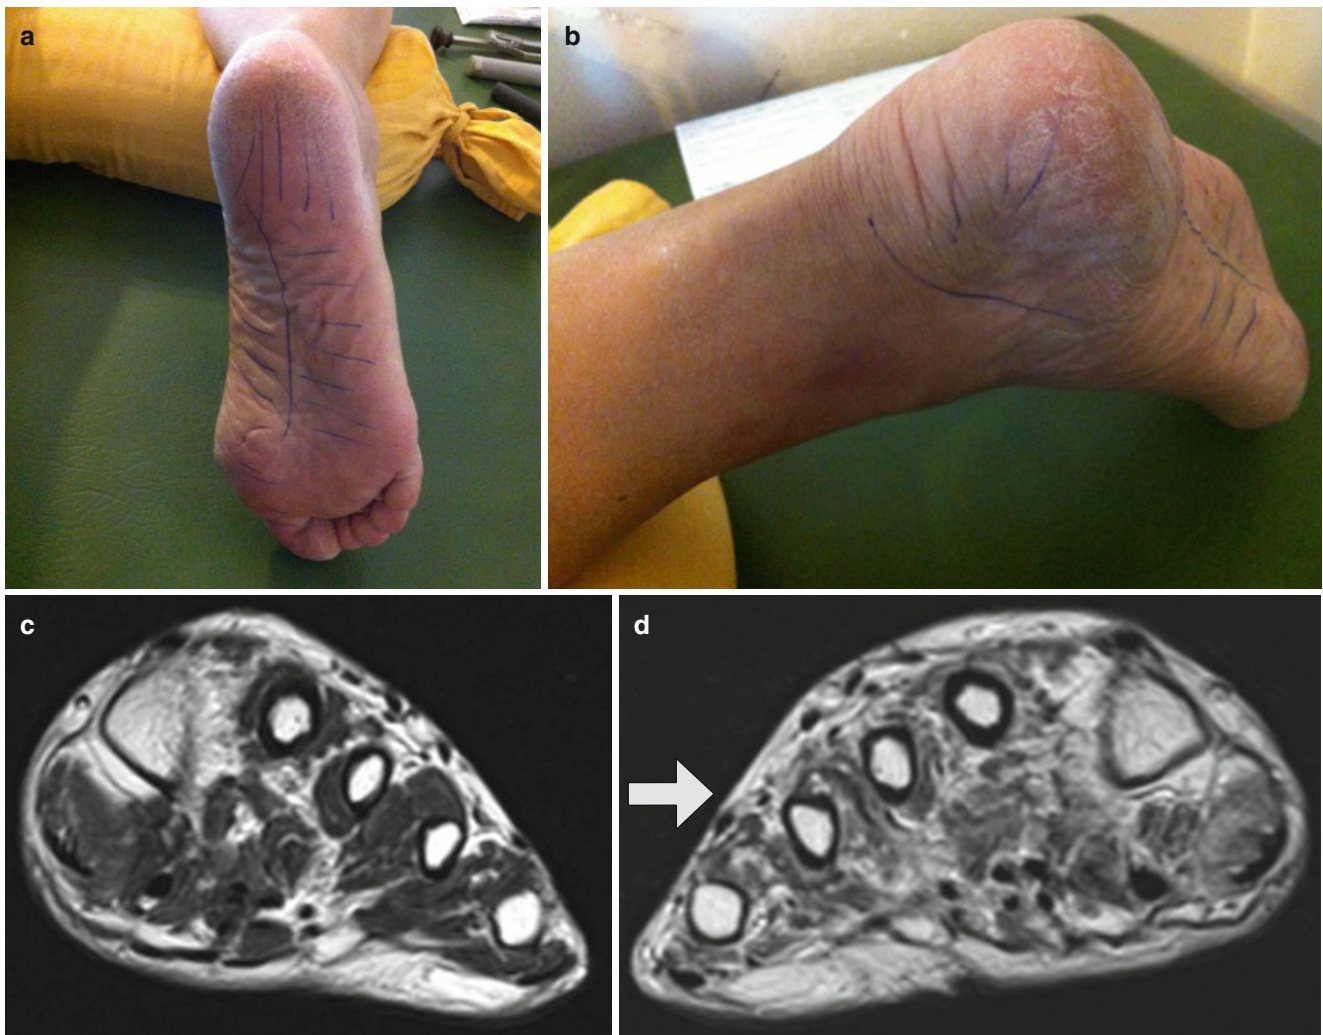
(a) Sensory loss in an incomplete tibial nerve lesion (after a knee operation). (b) Involvement of the calcaneal nerve. (c) MRI of the foot muscles of the left (healthy) foot. (d) Damaged muscles in the right foot due to denervation
